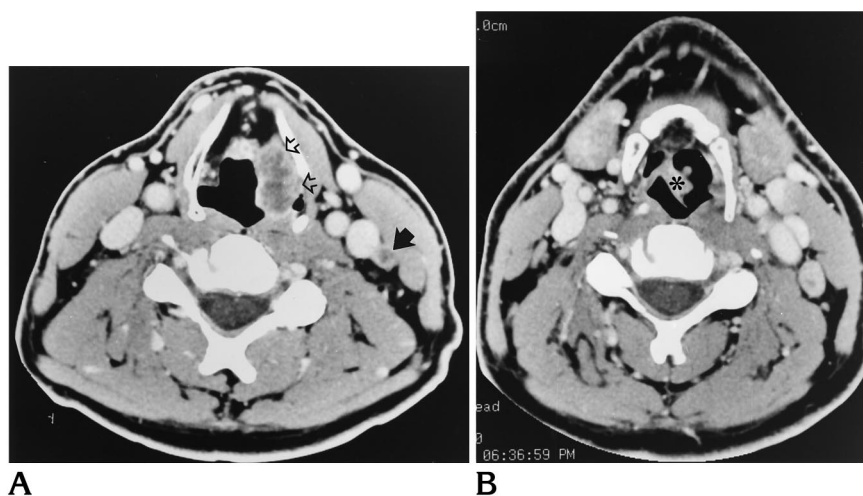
CT scans obtained at the time of diagnosis.
